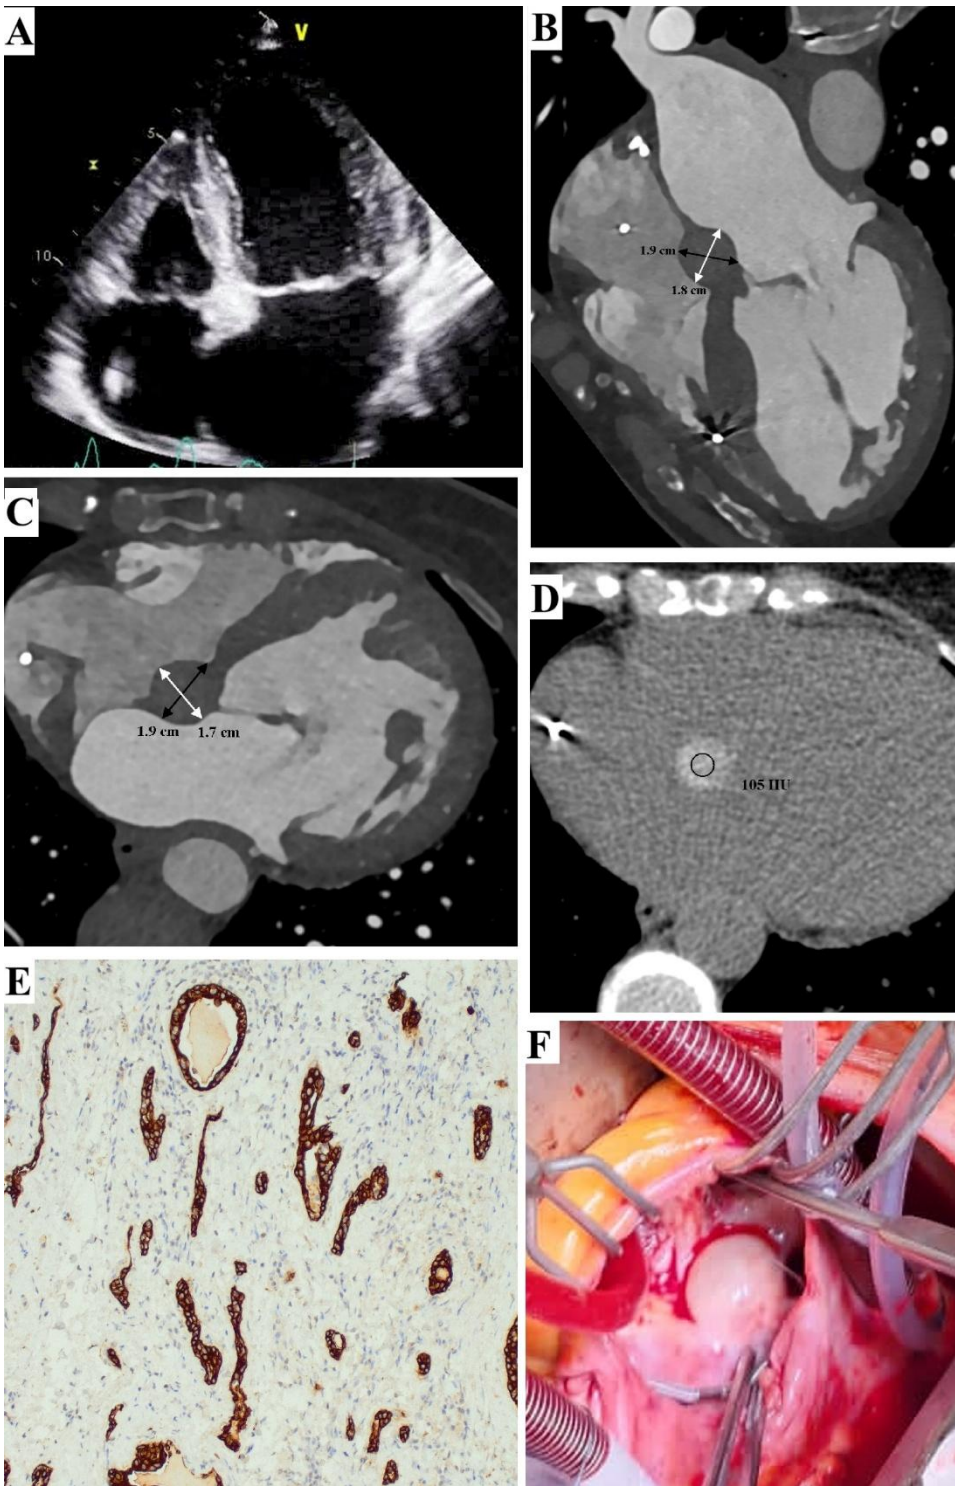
A. Apical 4-chamber 2-dimensional transthoracic echocardiography image showing a round echogenic mass in the right atrium, in the lower part of the interatrial septum, measuring 22×16 mm; B.–D. cardiac computed tomography (CT) scan showing a smoothly contoured oval lesion in the interatrial septum above the atrioventricular valves, measuring approximately 1.9×1.8 cm on long-axis, 4-chamber multiplanar reconstruction images (B) and approximately 1.9×1.7 cm on axial images (C); the native density of the lesion is approximately 80–110 HU (D), with postcontrast enhancement; the CT image suggests a cystic tumor of the atrioventricular node; E. the cell lining of cystic structures showed cytokeratin (AE1/AE3)
